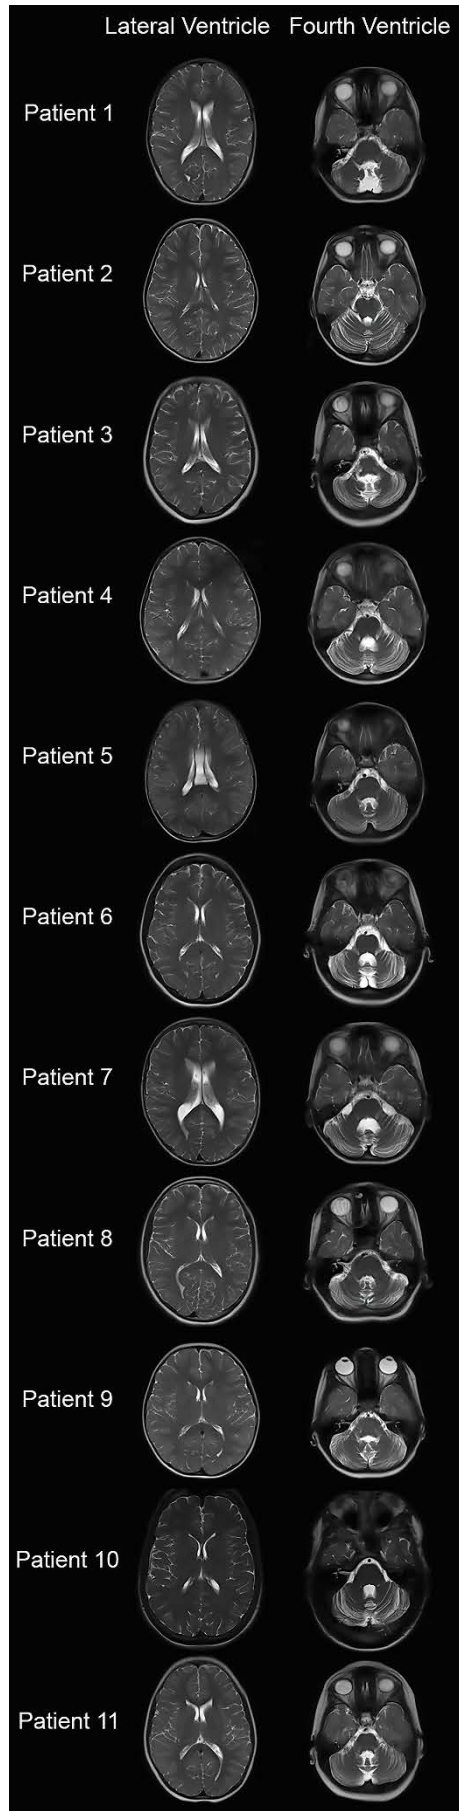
(Chapter 3). Axial T2-weighted MRI scans of the lateral ventricle and fourth ventricle in numbered ataxia-telangiectasia subjects.
